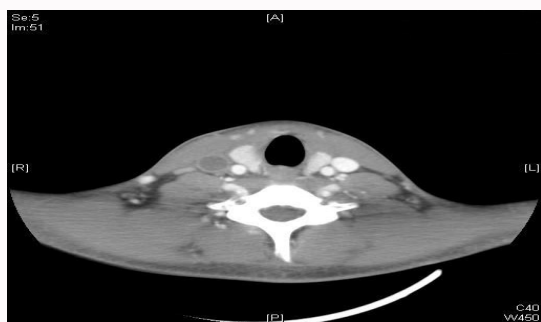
CT neck- Right internal jugular vein thrombosis.
